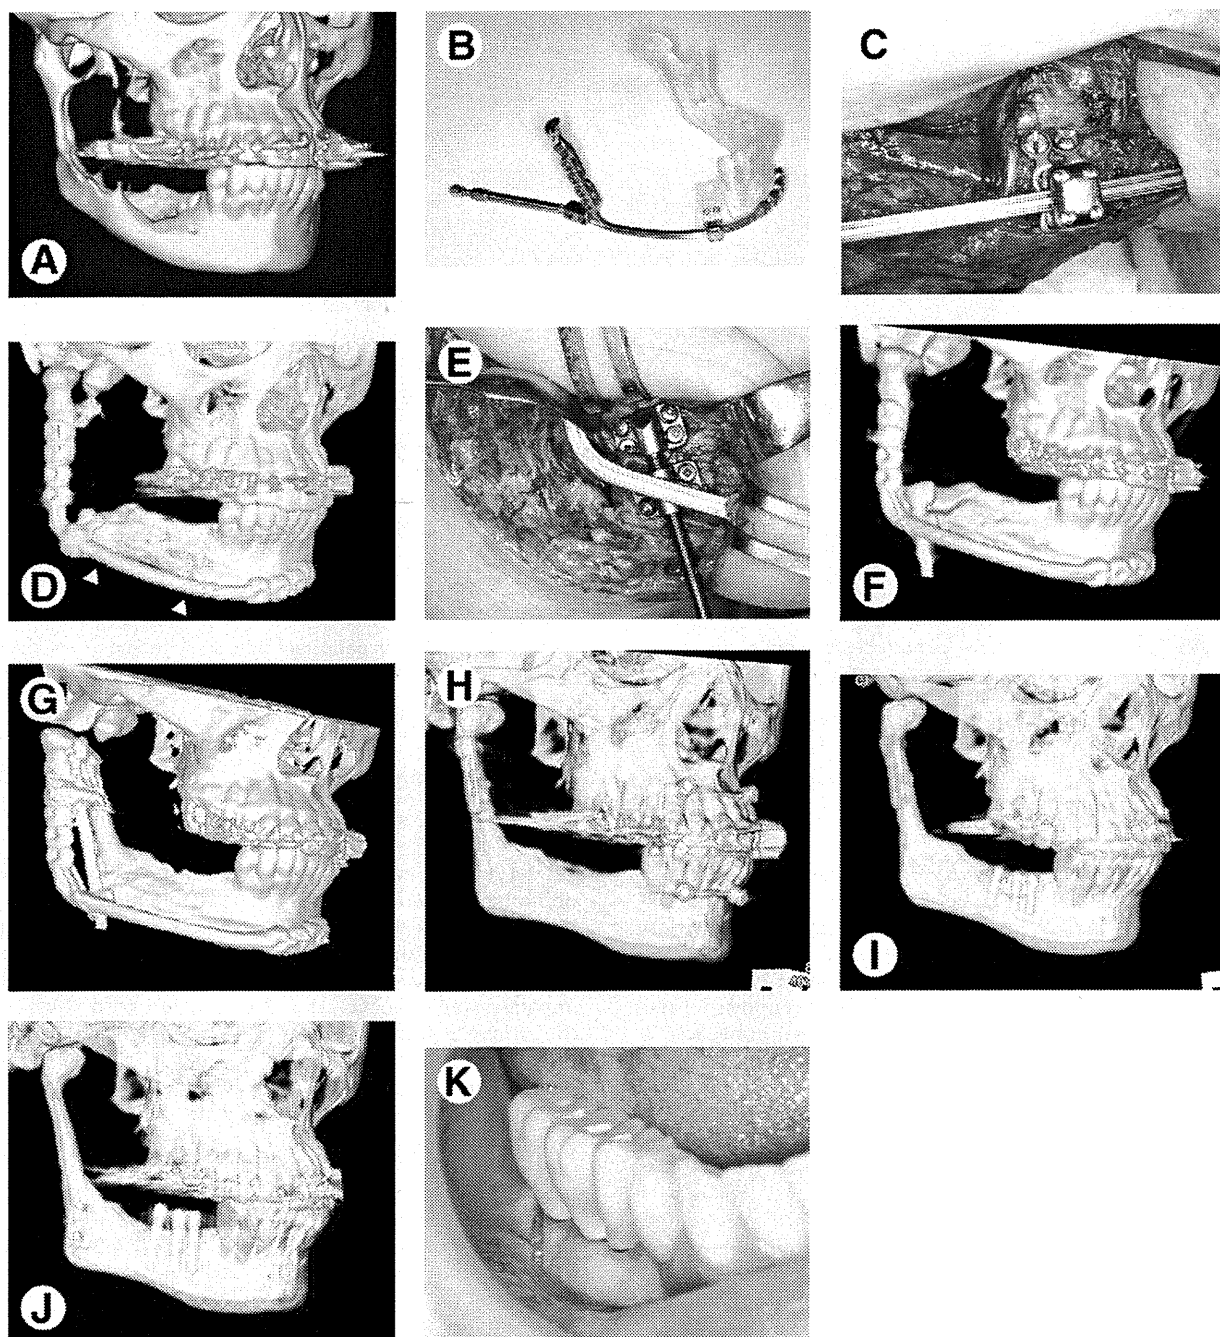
A, The mandible with a recurrent ameloblastoma. Computed tomography (CT) revealed a multilocular radiolucent image in the ramus and posterior body of the mandible. B, A custom-made distraction device with an artificial condyle on the patient's stereolithographic model. Locking plates and screws enabled suprapariosteal fixation of the transport segment. C, Suprapariosteal fixation of the distraction device. A short buccal periosteal flap of the transport segment was repositioned and sutured to cover the vertical osteotomy line. The transport segment was fixed with locking plates and screws suprapariosteally. D, The regenerated posterior mandibular body. Eight months after distraction, CT showed that newly formed 50-mm-long bone in the distraction gap (arrowheads) progressed to continuous buccal and lingual cortical surfaces. E, The secondary vertical distraction osteogenesis for reconstructing the ascending ramus. A short buccal periosteal flap of the secondary transport segment was repositioned and sutured to cover the horizontal osteotomy line. The transport segment was fixed with another distraction device and positioning screws suprapariosteally. F, Another transport segment. Immediately after surgery, CT showed the secondary transport segment fixed with the distraction device. G, The regenerated ascending ramus. Nine months after the secondary distraction, CT showed that newly formed bone in the distraction gap progressed to continuous buccal and lingual cortical surfaces of the ramus. H, Device removal and mandibular reconstruction. CT showed that the regenerated ramus is connected to the preserved condylar segment with a lag screw and plate. I, The regenerated mandibular body containing implants. CT showed 3 screw-type implants installed in the right second premolar and molar regions with a buccal veneer bone graft fixed with 2 screws. J, The reconstructed mandible and the osseointegrated implants for occlusal function. CT showed that the mandibular angle was adjusted with osteotomy and screw fixation in the angle region. K, A provisional implant-supported prosthesis on the reconstructed mandible. The ridge supporting the implants was surrounded by the attached mucosa, the buccal part of which originated from the palatal mucosa.
